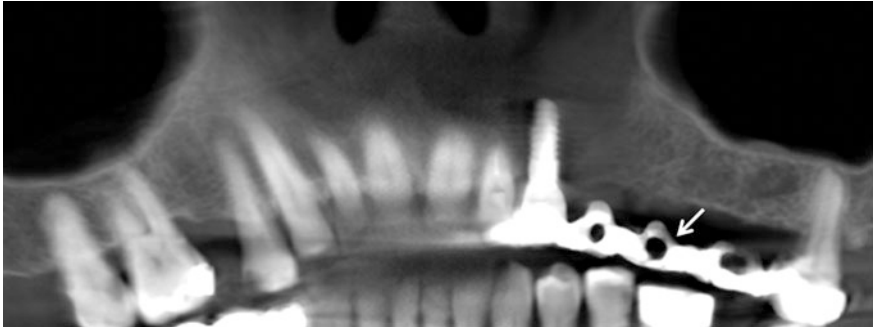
CBCT panorex: note the implant screw in left maxilla with a fixed bridge (*thin arrow*)
